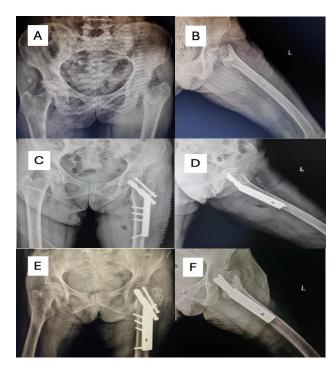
Case 2 (A and B) pre-operative radiographs; (C and D) immediate post-operative radiograph; (E and F) 1-year postoperative follow-up radiograph showing cutout).
